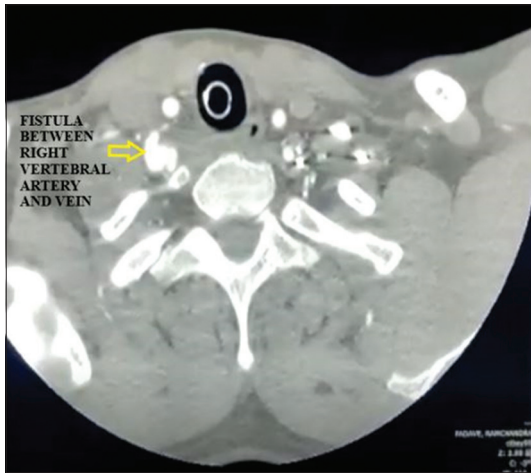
CT vertebral angiogram showed a fistulous communication between the right vertebral artery and vein at C7–T1 level
